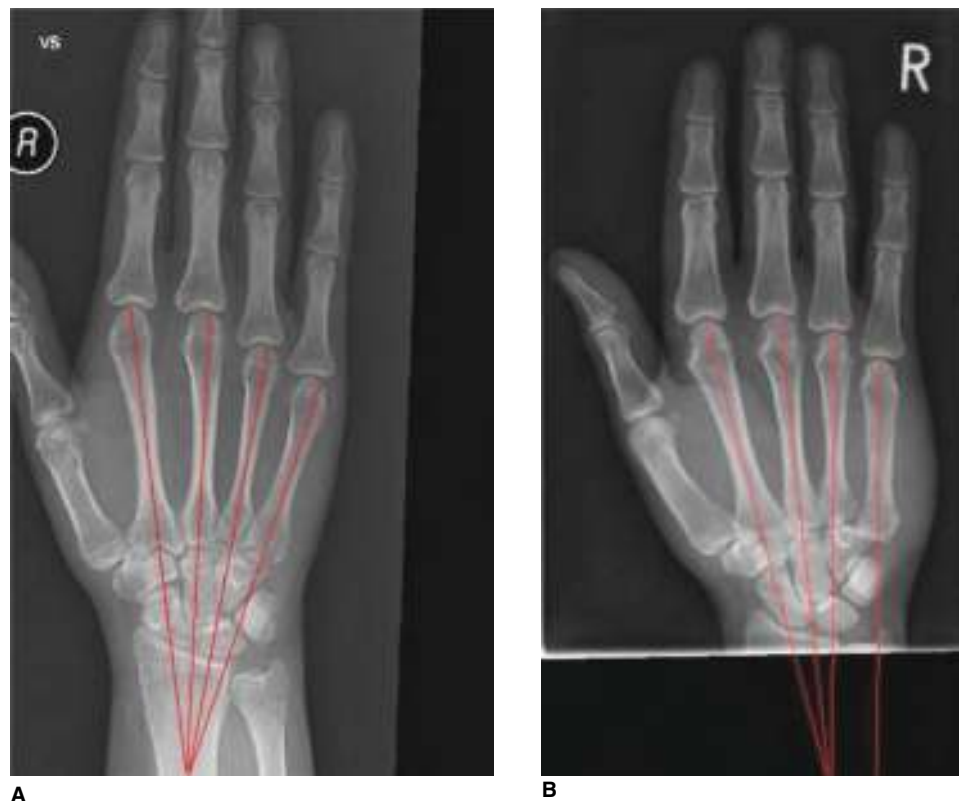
The PA radiograph metacarpal cascade line technique. A. Normal convergence. B. Abnormal convergence seen in a dislocation. (Used with permission from reference 18.)
